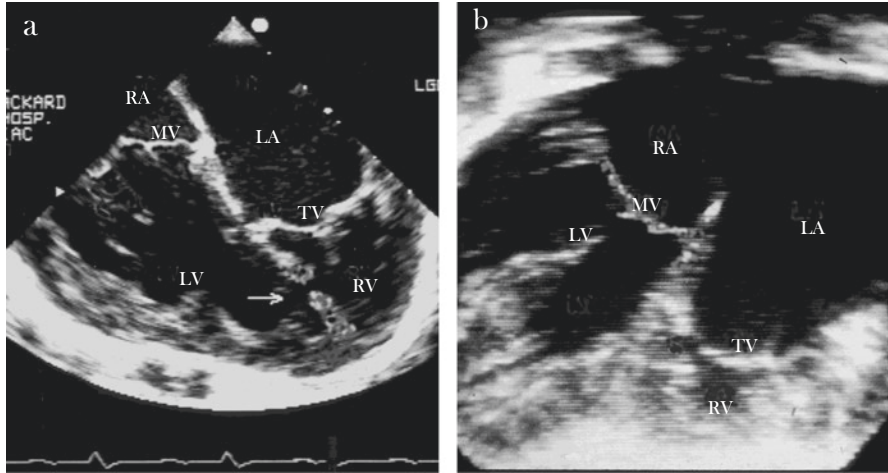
Four chamber echocardiographic sections from two hearts with discordant atrioventricular connection and Ebstein's malformation of the TV. (a) The cardiac apex directed to the right and (b) the apex to the left. The arrow highlights a small muscular VSD. In each case, the TV is displaced from the atrioventricular junction into the left sided morphologically RV
